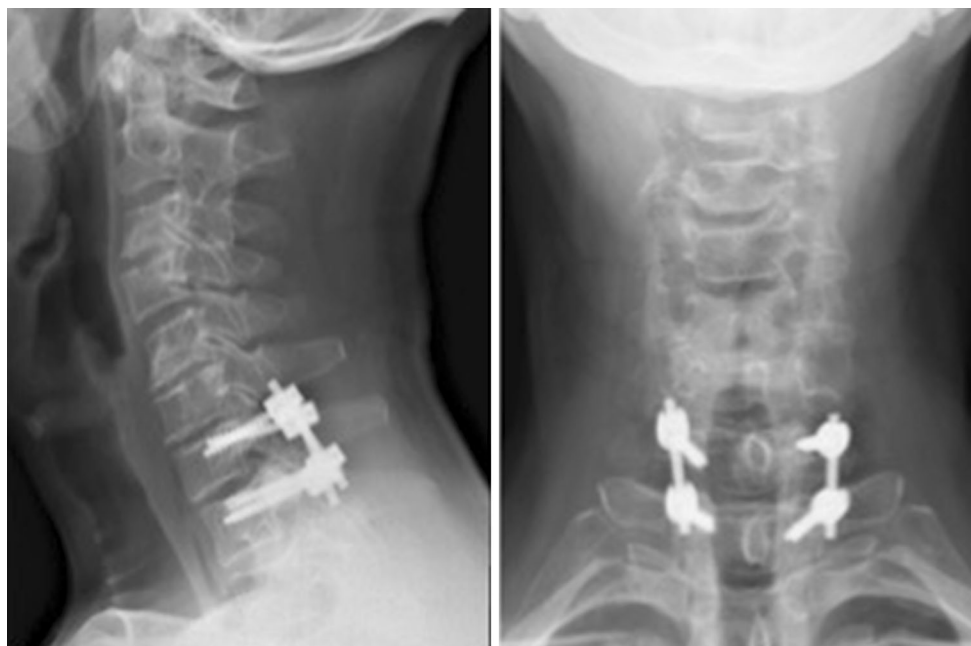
Lateral and antero-posterior X-ray views of the cervical spine at 1-year follow-up
